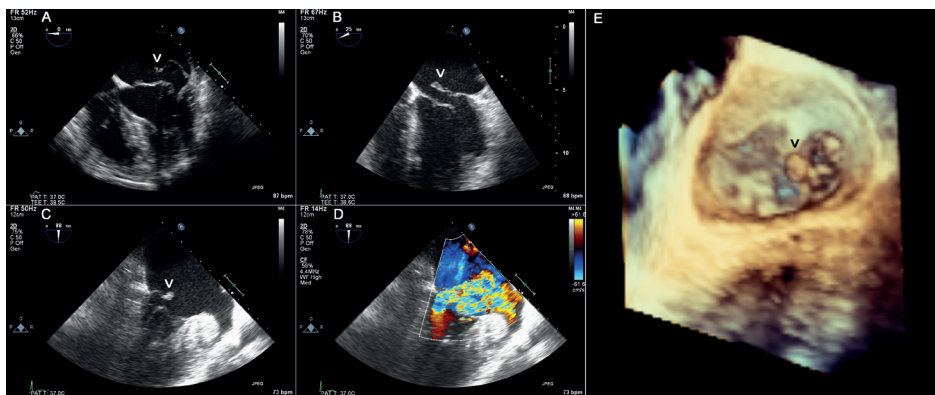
Type II-A mitral valve prolapse due to fibro-elastic deficiency with chordal rupture (A, see arrow-head). Acute flail mitral valve leaflet prolapse due to antero-lateral papillary muscle rupture (B, see arrowhead) and postero-medial papillary muscle rupture (C: gray-scale, see arrowhead, D: color Doppler, E: 3D image, see arrowhead).
